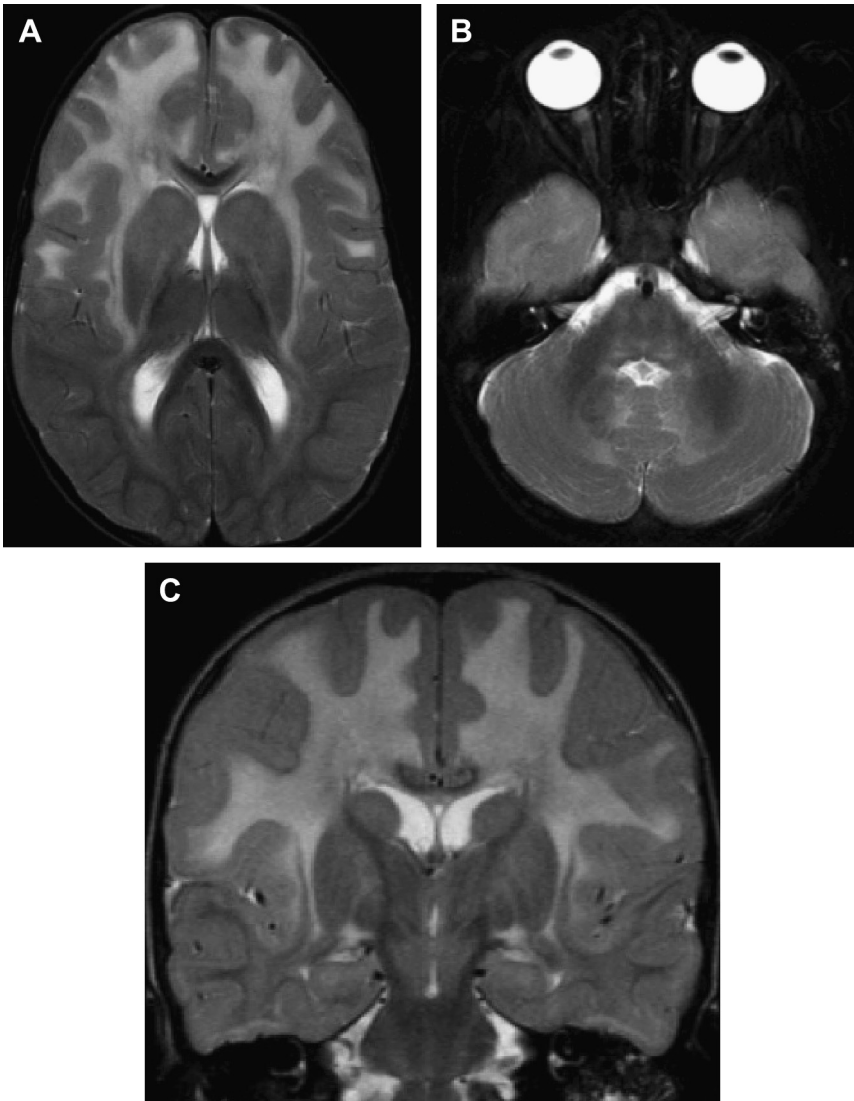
Five-year-old child with Alexander disease. Axial (A, B) and coronal T2-weighted (C) images of the brain demonstrate expansile frontal subcortical white matter signal abnormality extending to the ventricle and signal increase within the basal ganglia, to a lesser extent also the brainstem. In the setting of macrocephaly, this appearance is virtually pathognomonic of Alexander disease. Other classic features not demonstrated in this case include enhancing areas of white matter T1/T2 shortening.
